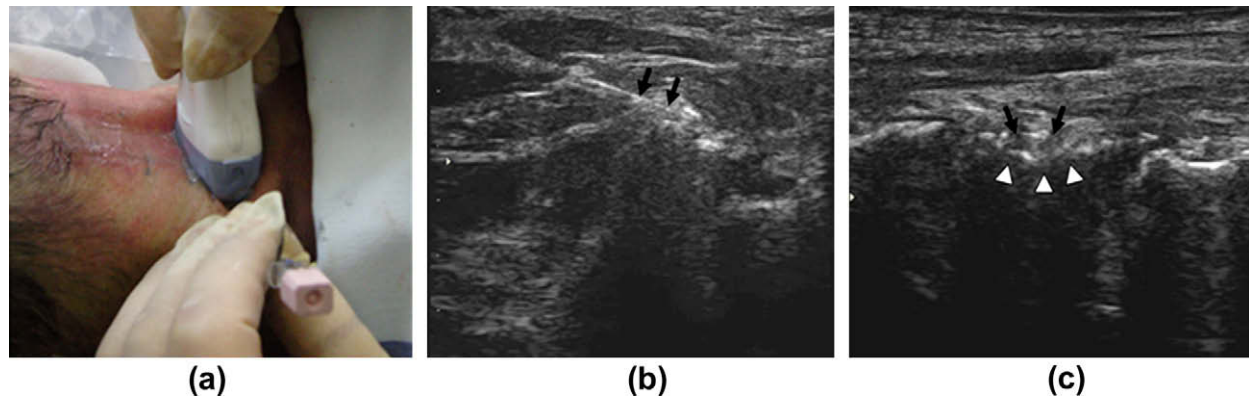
Under real-time ultrasound guidance (a) a 20 G, 10 cm needle was inserted at the medial end of the transducer exactly in the ultrasound plane. Cross-axis (b) and long-axis (c) views show the needle tip (arrows) was placed at the target point in which the C5 cervical medial branch crosses the waist of the ipsisegmental articular pillar (arrowheads).
